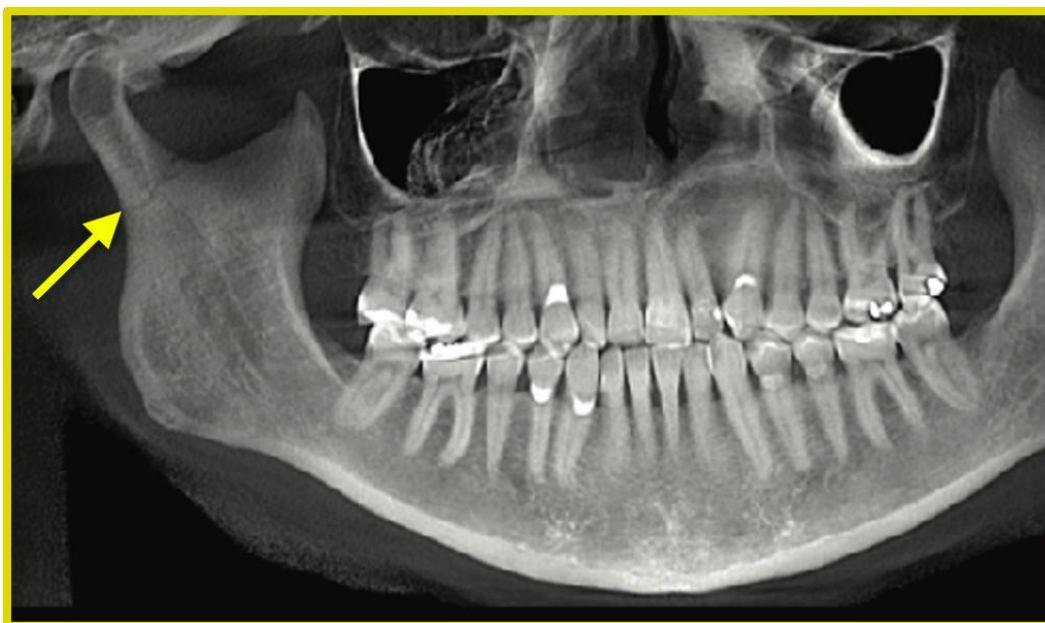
Panoramic radiograph shows a non-displaced fracture (arrow) through the buccal and lingual cortices of the right condyle.
